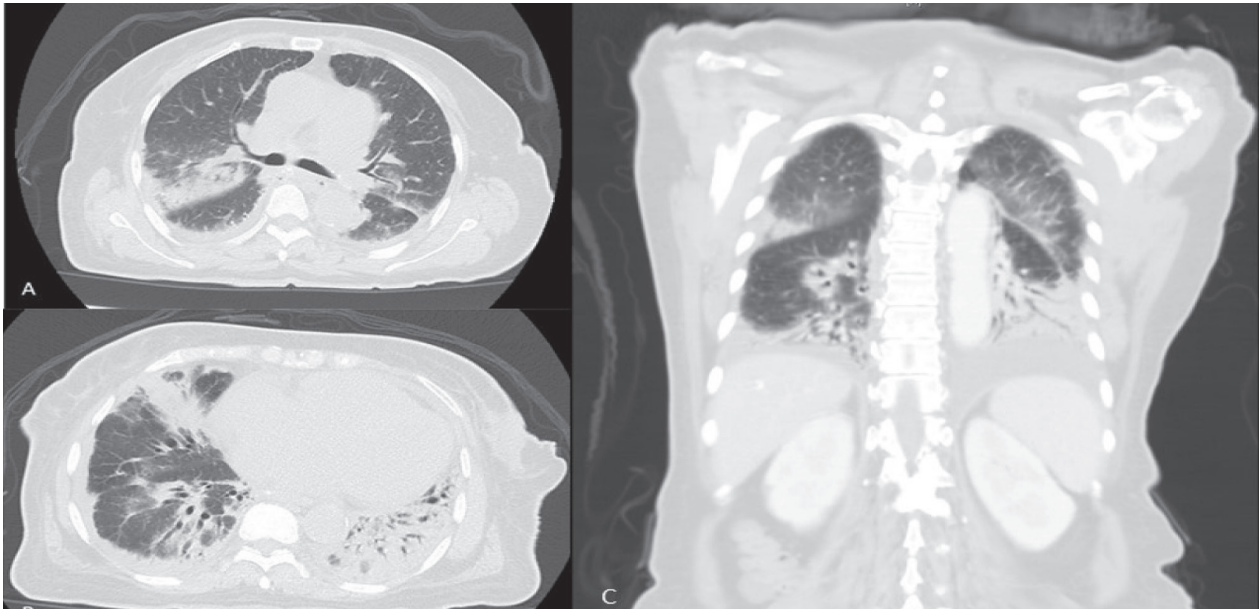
Chest computed tomography shows ill-defined consolidation with bronchograms in the bilateral lower lung fields.
